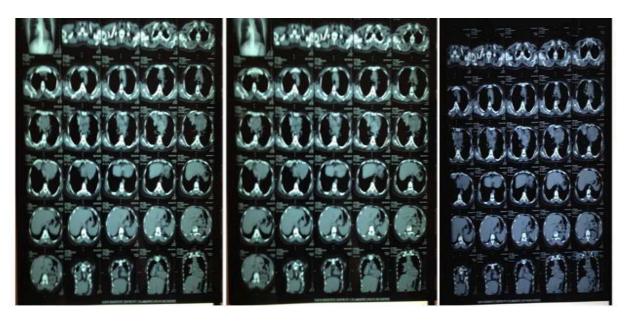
CT Chest Bilateral Lower zone infiltrations with central bronchiectasis.
